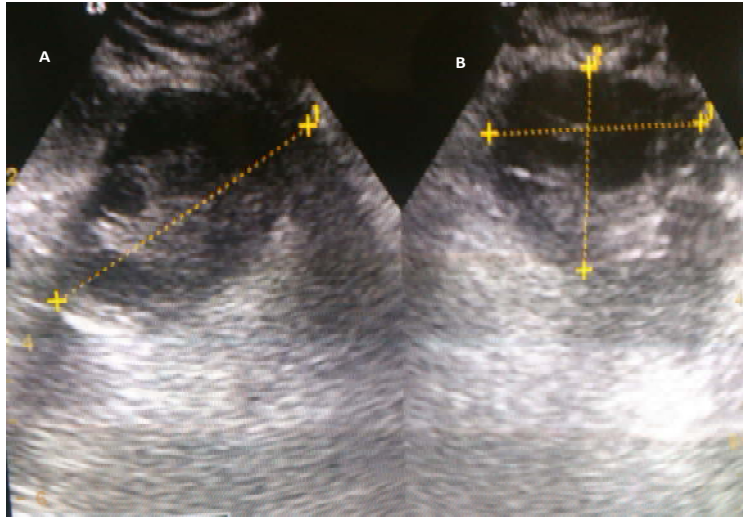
Transvaginal sonogram of the ovary demonstrating the length on the longitudinal plane (A) and the width as well as the antero-posterior dimensions on the transverse plane of the ovary (B)
